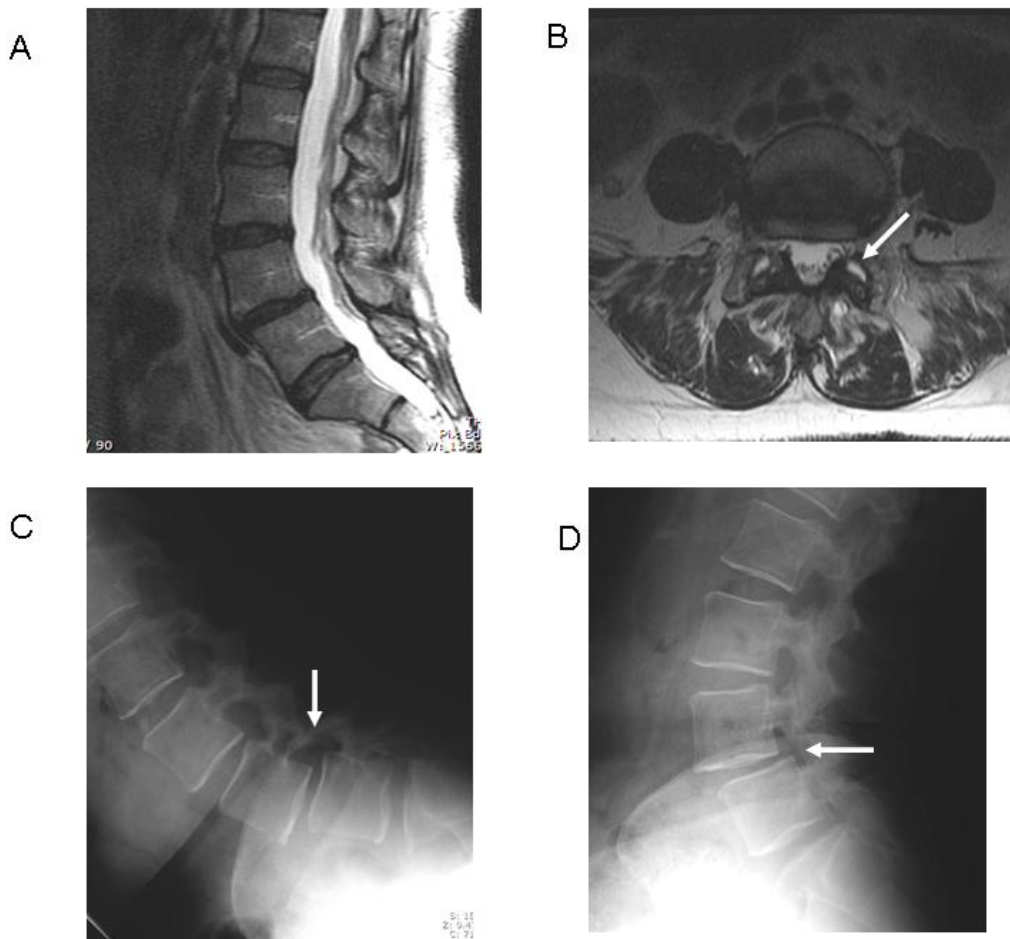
Additional images of the patient presented in the Figure 2 case example. These images are from a separate MRI obtained in the standing position (FONAR scanner). The sagittal image (A) demonstrates the L4-5 spondylolisthesis which was noted on standing films, but not supine MRI. The axial image through the L4-5 level (B) demonstrates that the exaggerated fluid in the facets which was seen on the supine imaging of this patient is no longer visible.
